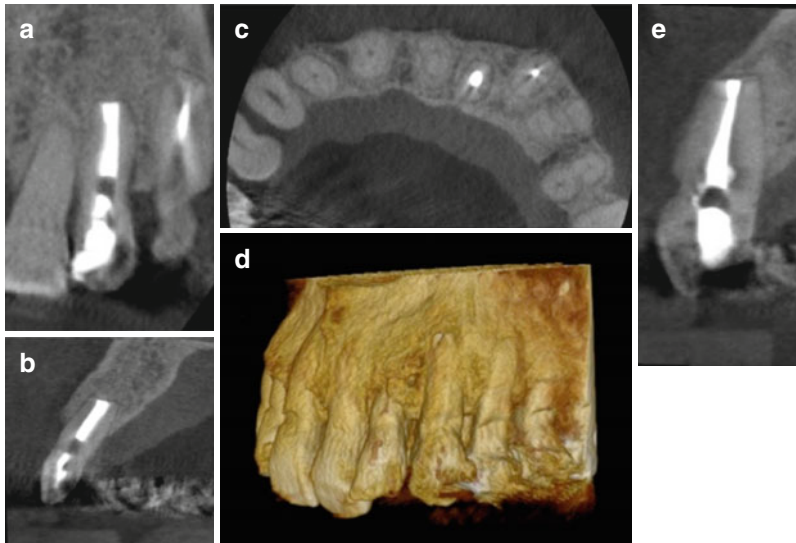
Continuation of case presented in Fig. 6.15: 2-year recall CBCT scan of teeth #10 and #11 demonstrating complete remodeling of the defect including the buccal and palatal cortical plates (a–e)
